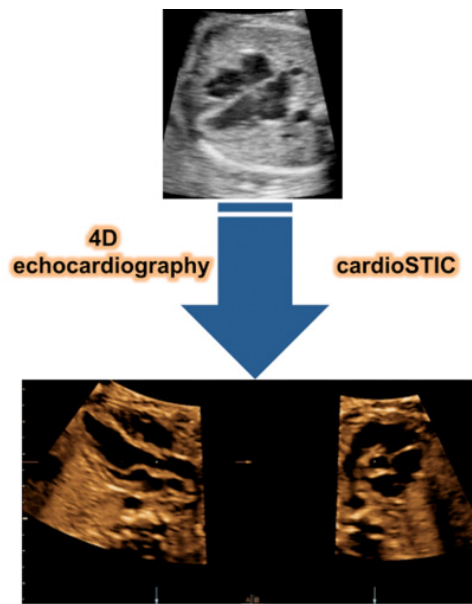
([video 1](#)) Possibility of obtaining the outflow tracts from the 4 chamber view using the “3 steps technique” [2] from acquired 4D cardioSTIC volume data sets. This approach can be also used to avoid unnecessary referrals for echocardiography to tertiary centers. Indeed the prevalence of CHD in pregnant women with traditional risk factors is extremely low and as shown in Fig. 2.
